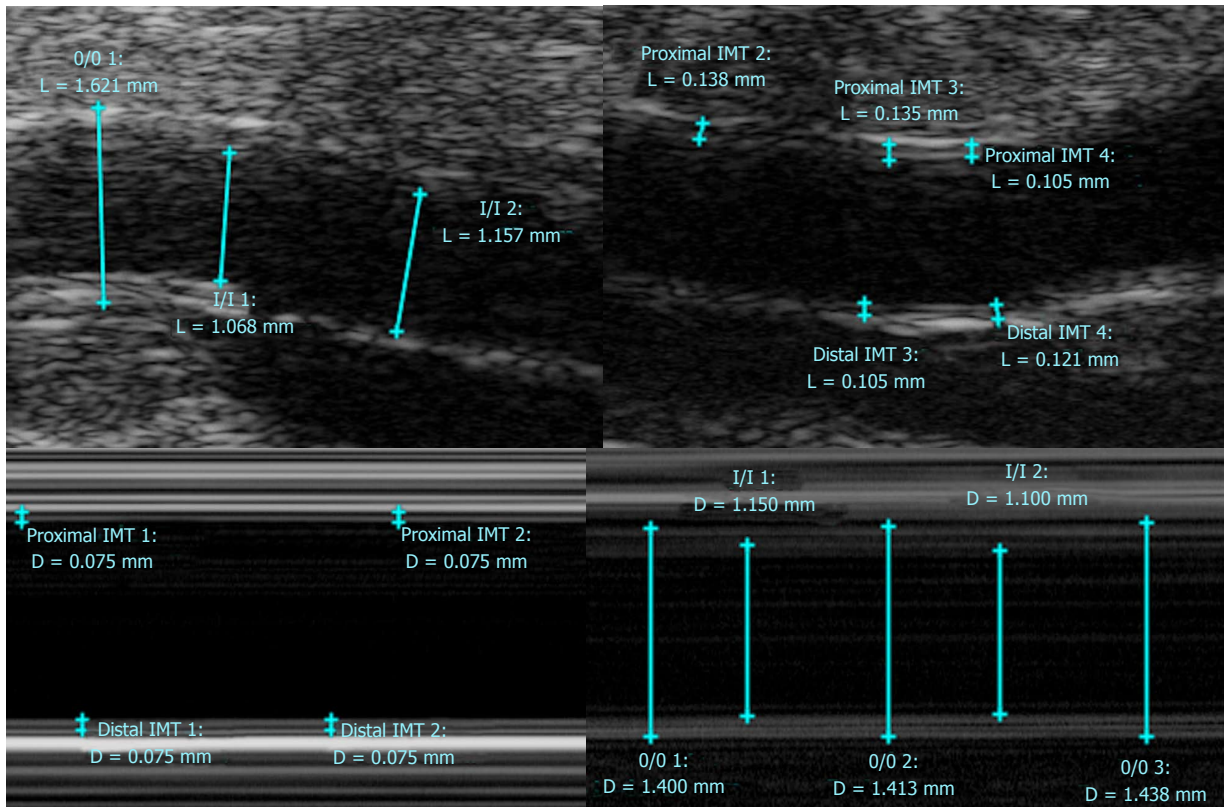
Ultrasound Images (B mode, M mode).
